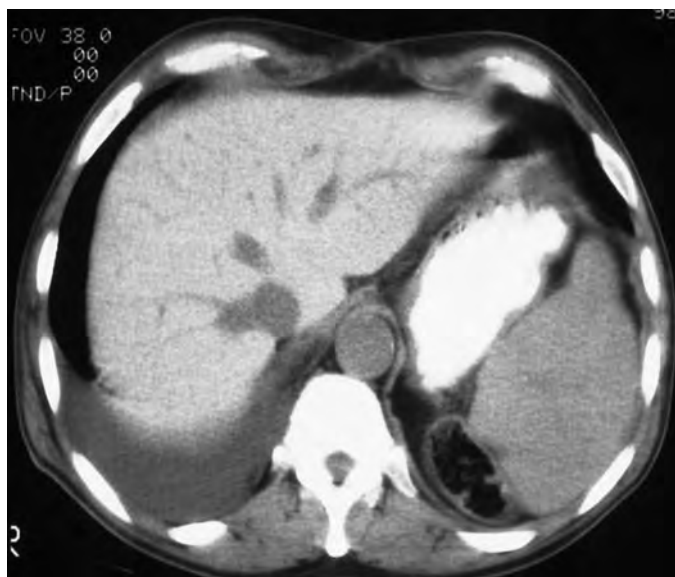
Amiodarone hepatotoxicity. Non-contrast-enhanced CT scan of a cardiac patient who had been taking amiodarone demonstrates a liver with an abnormally high attenuation compared with the spleen. Note how the hepatic blood vessels are highlighted by the dense parenchyma. The appearance is indistinguishable from that of hepatic iron overload. There is a right-sided pleural effusion.
